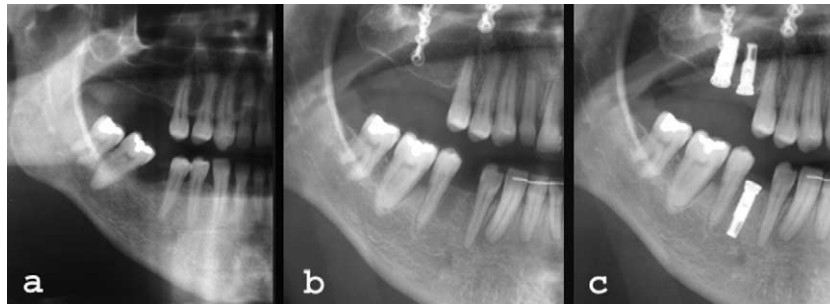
Orthopantomography of right side. a, Before treatment; b, after treatment; c, after implantation.
